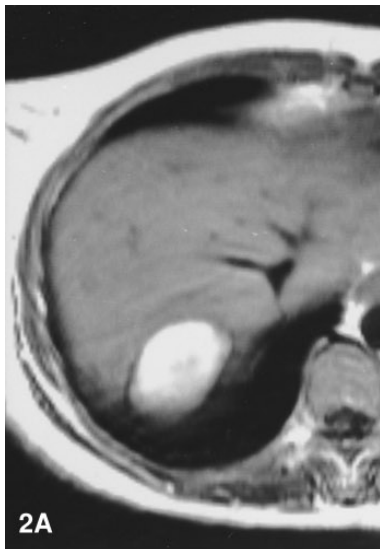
Hepatocellular adenoma with hemorrhage. Hyperintense subcapsular lesion is shown on all sequences. A T1-weighted SE image (420/15). B Fat-suppressed T1-weighted images (420/15). C T2-weighted SE image (2200/90). A hypointense rim is seen around the lesion, denoting hemosiderin deposition.
